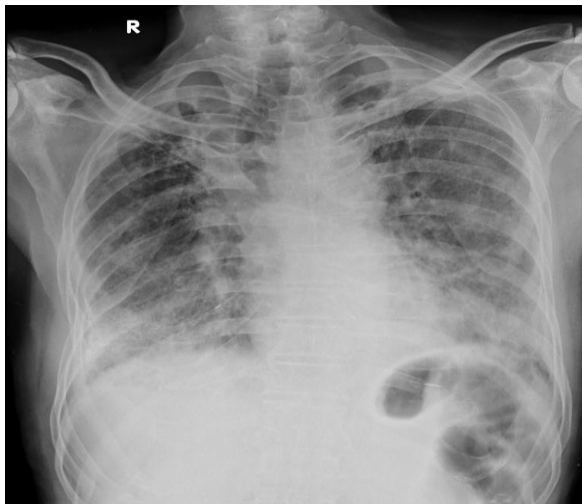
Chest X-Ray PA VIEW Cavitary lesion noted in the right upper lobe- Sequelae of prior tuberculosis
